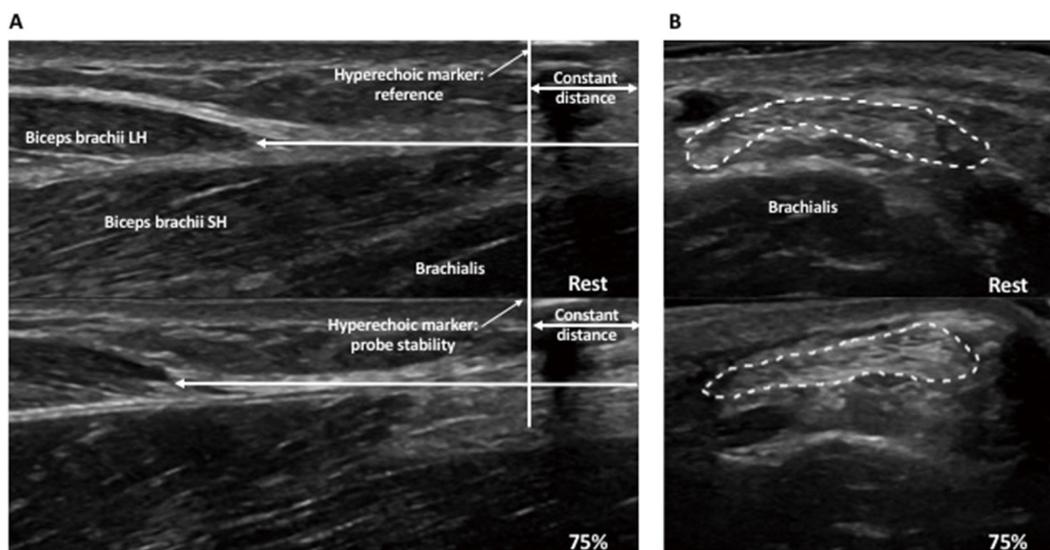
Representative ultrasound images of tendon elongation (A) and tendon CSA (B) of the dBB at rest (top panel) and 75% MVC (bottom panel). MVC, maximal voluntary contraction; dBB, distal biceps brachii tendon; LH, long head; SH, short head
